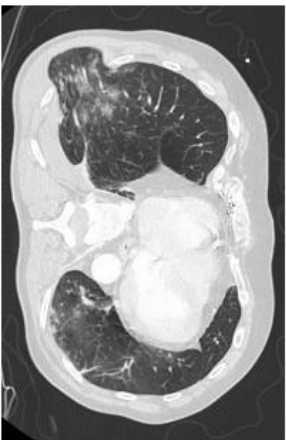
Transverse cut of CT Chest (Lung Window) noting a 5.3 cm posterior lung hernia.
